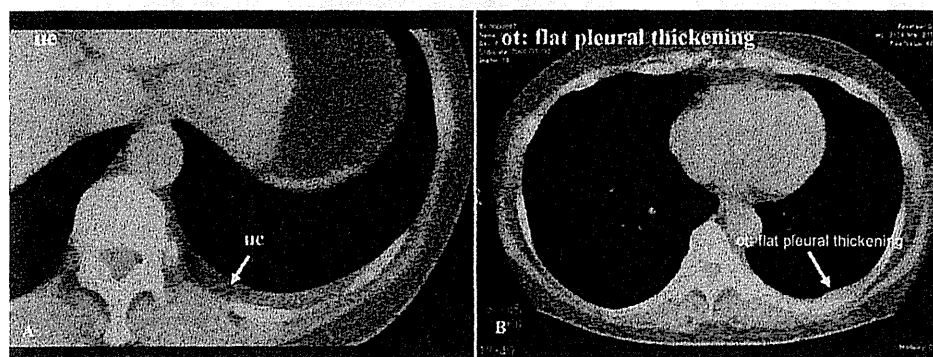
A 52-year-old woman with diffuse epithelioid MPM. CT scans show slight unilateral pleural effusion (A) and flat pleural thickening in the left hemithorax (B). According to the CT appearance, the MPM probability was agreed as low probability Grade 2 at mild severity by experts.
